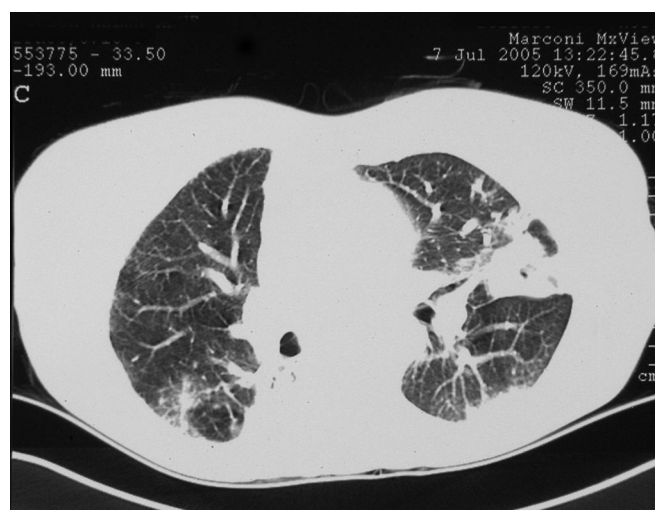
Chest computed tomographic scan after 3 months' treatment with Erlotinib.
